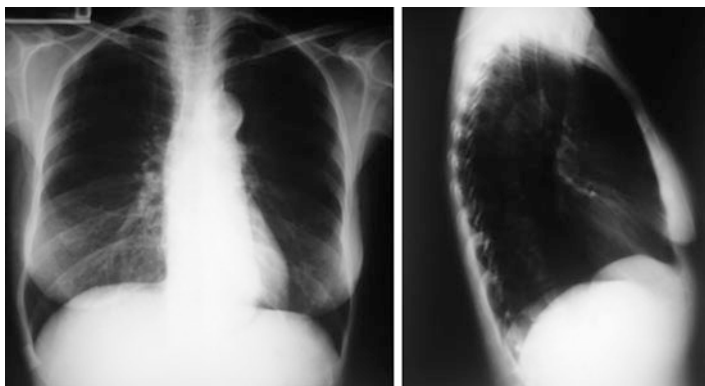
X-rays – presence of aortic knob calcifications
